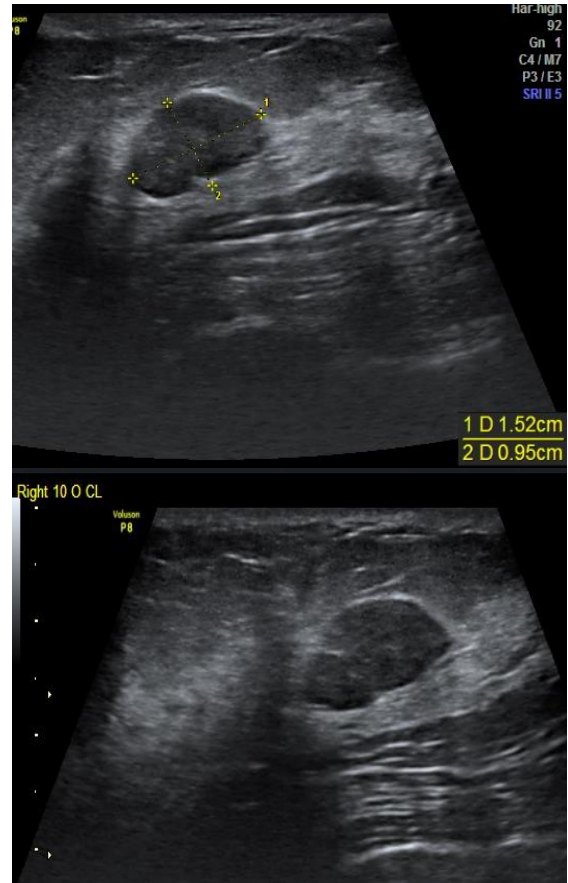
(a,b): 31 years old female with Fibroadenosis. Transverse sonographic image, showing an oval shape, hypoechoic mass with thin, echogenic capsule in right upper outer quadrant at 10'o clock position.
